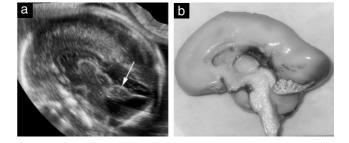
Dandy–Walker malformation in a 21-week fetus. The transvaginal sonogram (a) failed to demonstrate the anatomic landmarks of the cerebellar vermis (arrow), fastigium and fissures, and we were uncertain whether this reflected hypoplasia. After termination of pregnancy, autopsy revealed a normally lobulated vermis (b).
